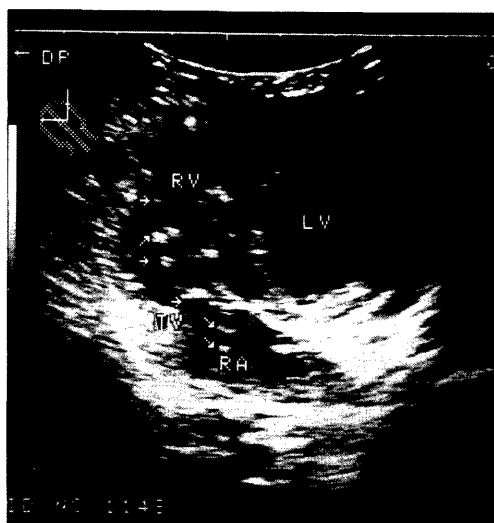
Two-dimensional echocardiogram at the time of heartworm migration. RV: Right ventricle, LV: Left ventricle, TV: Tricuspid valve, RA: Right atrium, Arrow: Heartworm echo.
